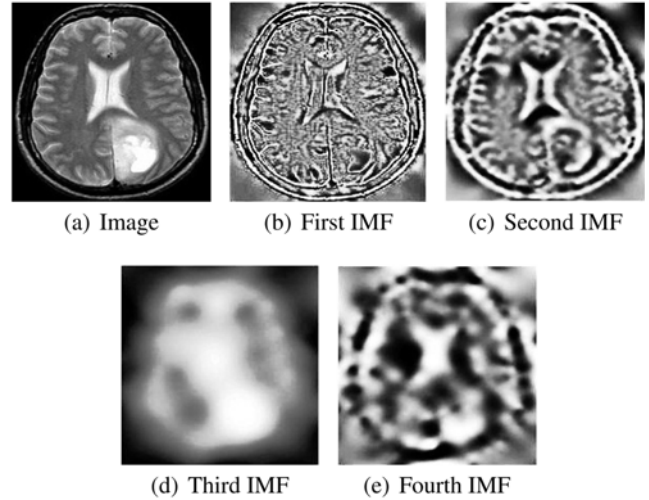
Sample abnormal brain MR image and corresponding IMFs.
